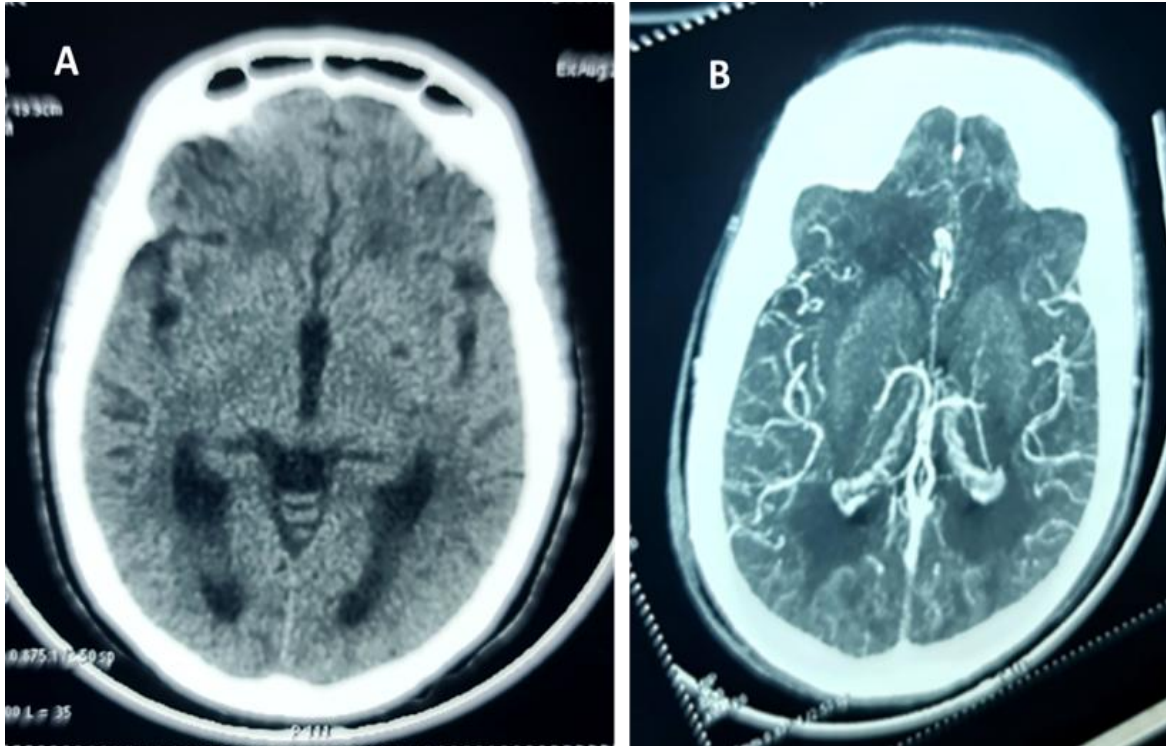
Cerebral CT (A) with angiographic acquisition (B) showing lacunar left lenticular hypodensity suggestive of an ischemic lesion of the territory of the deep middle cerebral artery.
